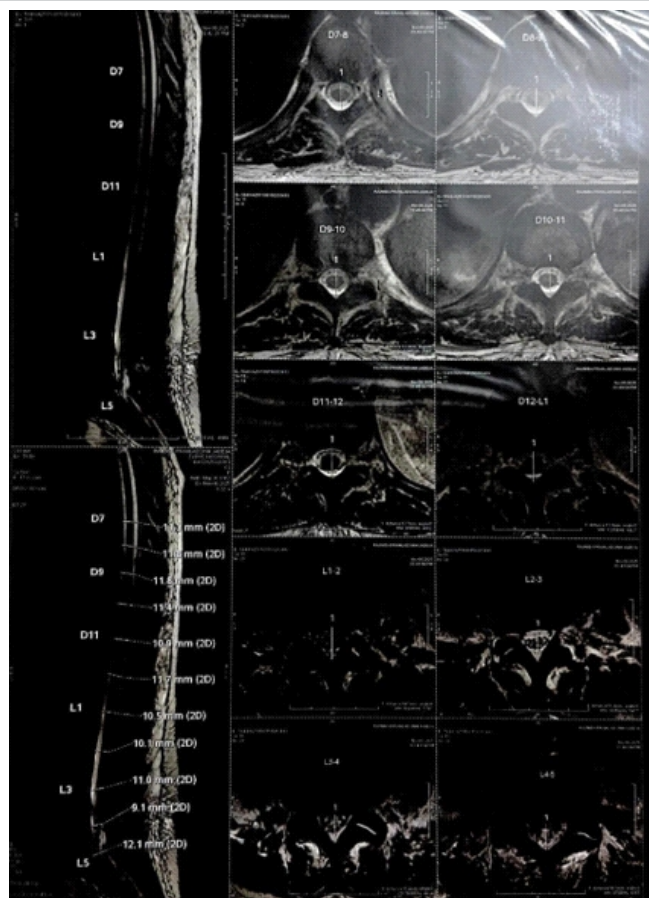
Magnetic resonance imaging (MRI) spine. Sagittal and axial T2-weighted and T1-contrast 3T MRI of the dorso-lumbar spine. Images depict focal altered signal intensity within the left pedicle, lamina, and posterior elements of the L3 vertebra, accompanied by facet joint effacement and diffuse posterior disc protrusions causing thecal sac compression.
